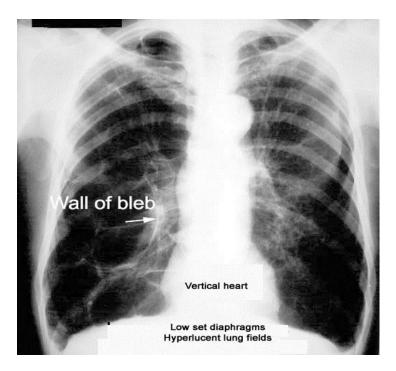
CHEST X-RAY OF COPD
